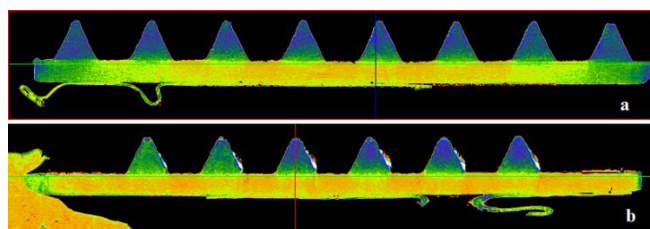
μ -CT images of (a) the back and (b) the side of the pyramid microneedle arrays.
